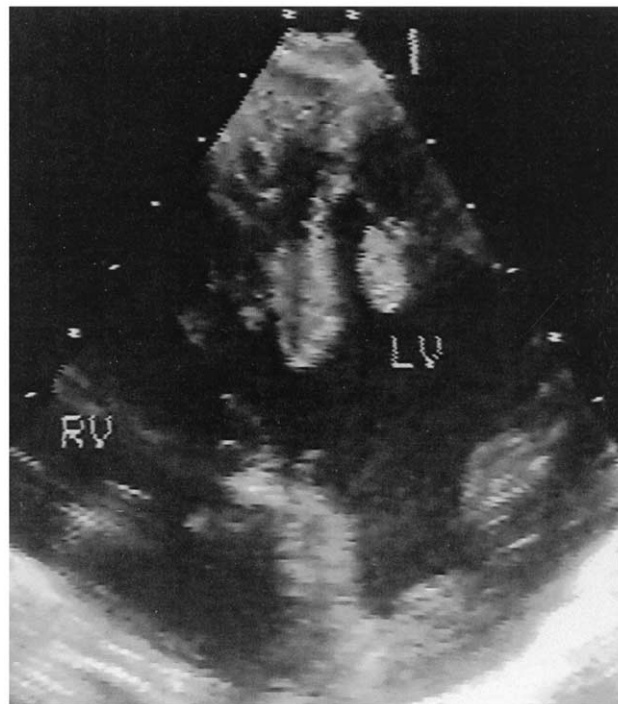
Transesophageal echocardiographic view of large midmuscular ventricular septal defect. (LV = left ventricle; RV = right ventricle.)
